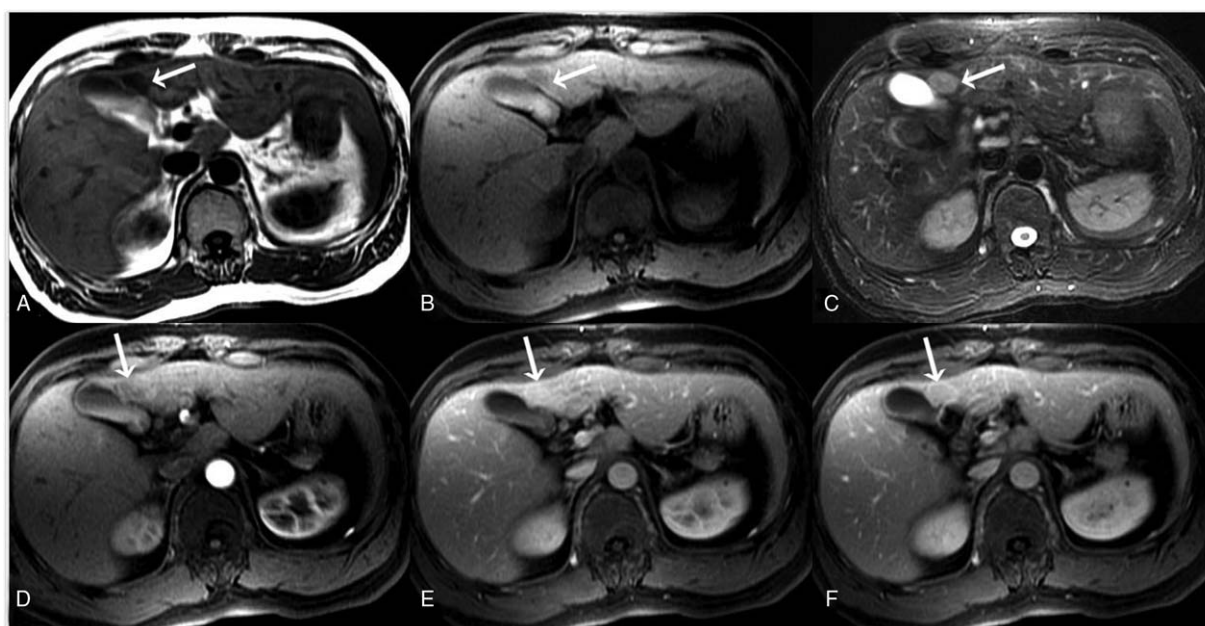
Magnetic resonance images of implanted hepatic splenosis. Magnetic resonance imaging showed a nodule in SIV which was homogenous hypointense on T₁WI (A and B) and hyper-intensity on T₂WI (C). On the gadolinium-diethylenetriamine pentaacetic acid dynamic-enhanced images, this nodule showed marked enhancement in the arterial phase (D) and portal venous phase (E) and appeared a hypointense lesion compared with the surrounding liver parenchyma in the equilibrium phase (F). In addition, its rim had obvious circular delayed enhancement during the enhancing process. SIV=segment IV, T₁WI=T₁ weighted imaging, T₂WI=T₂ weighted imaging.
